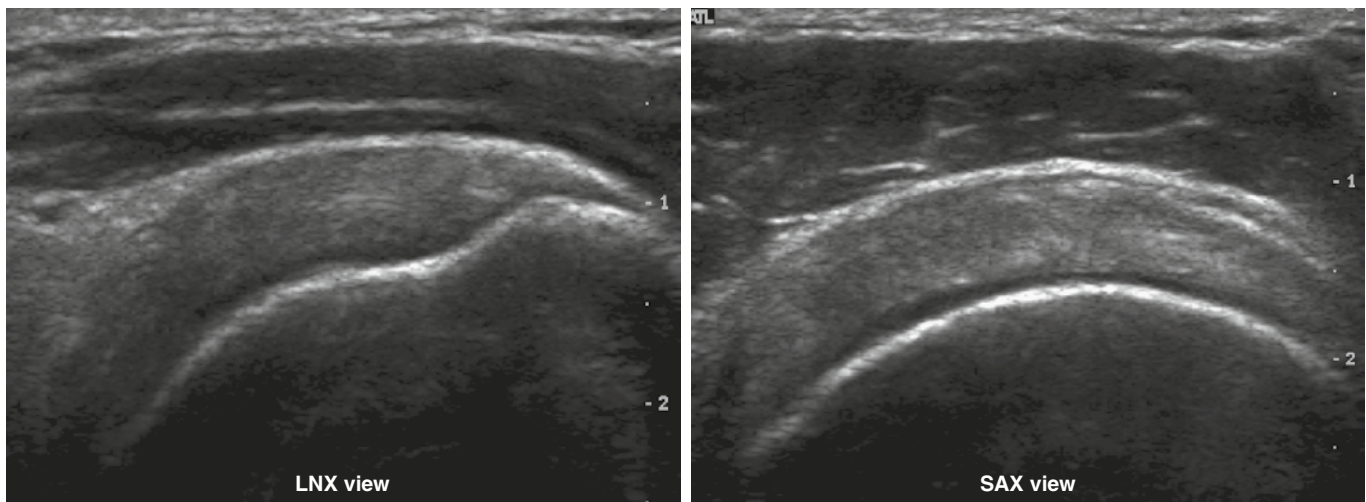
Ultrasound view of a normal supraspinatus tendon. LNX, long-axis; SAX, short-axis.
